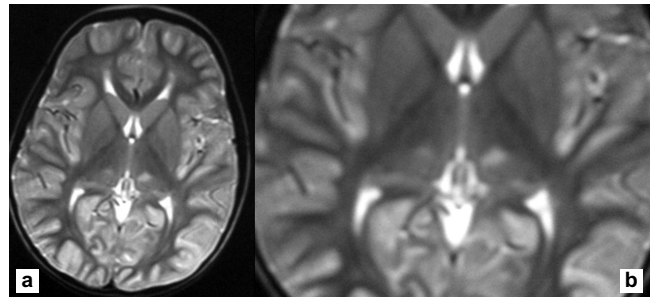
(a) Axial T2-weighted image shows symmetric increased signal intensity in the thalami. (b) The enlarged image of the same lesion.
